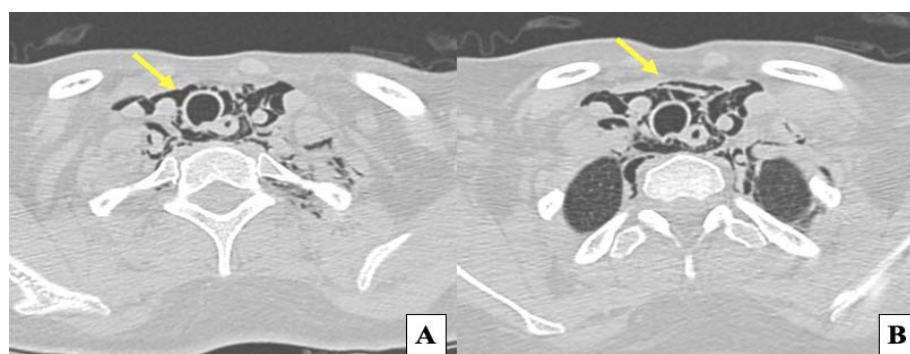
Axial Chest CT images in lung window at the level of the lower neck (A) and pulmonary apices (B) showing extensive emphysema (arrows).
